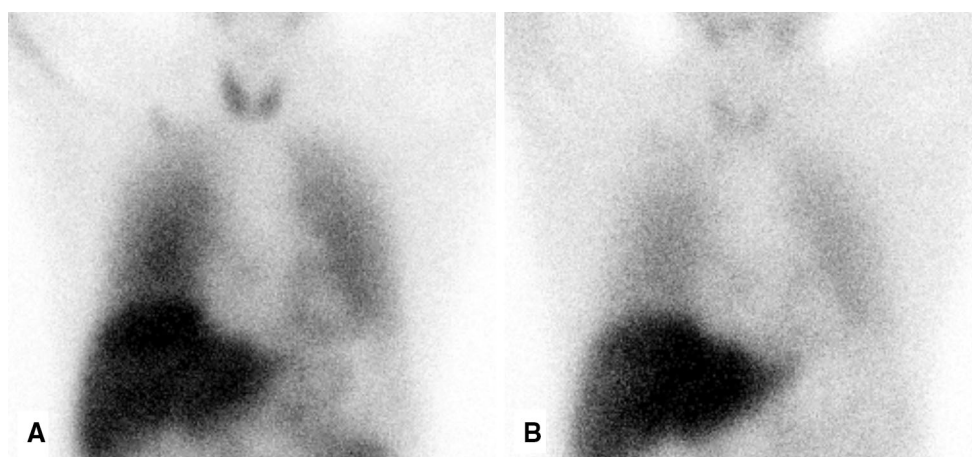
Abnormal [^{123}I]-MIBG scintigraphy in a patient with ATTR amyloidosis. a Early image acquired after 15 min after tracer administration, b late image acquired after 4 h post injection.
